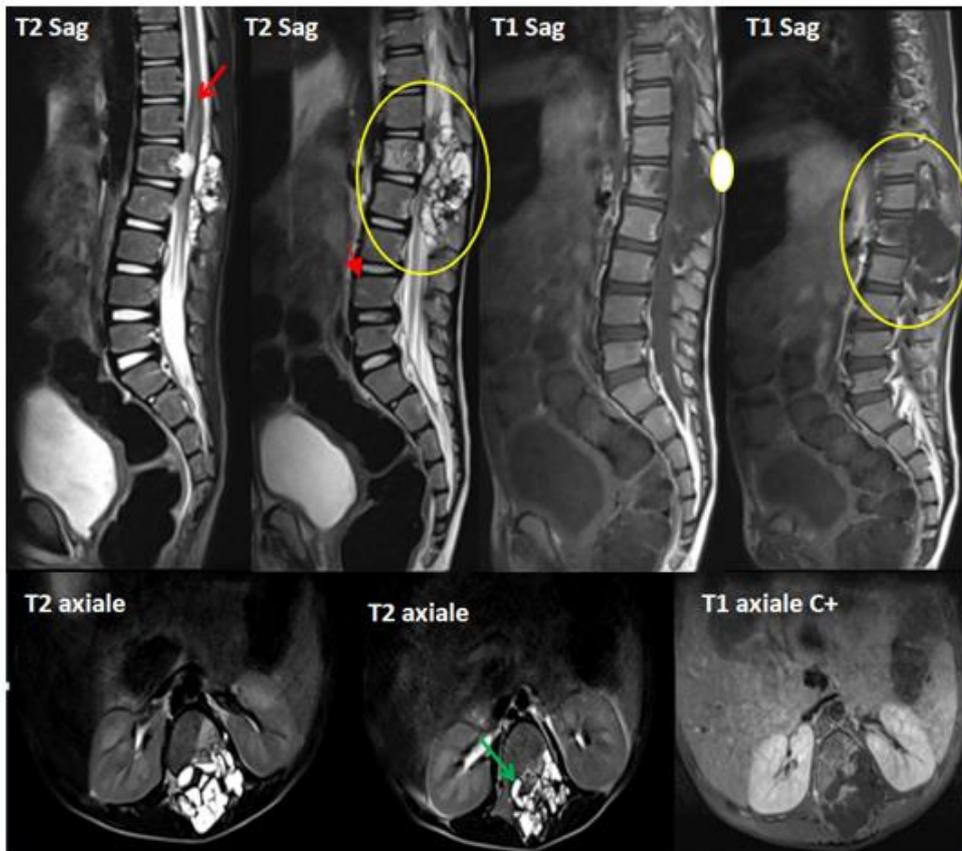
Sagittal and axial spinal MRI images with T2-weighted, T1-weighted sequences, and post-contrast injection demonstrate a multi-loculated cystic lesion involving the anterior and posterior epidural spaces, as well as the left middle and posterior arches, extending from D12 to L4 (yellow circle), resulting in spinal cord compression and compression of the cauda equina roots (green arrow), with medullary compromise at the level of L1 (Red arrow)
